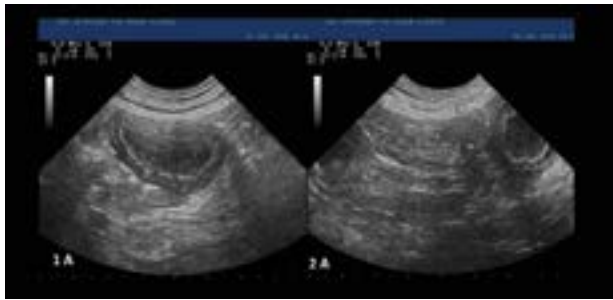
1A Ultrasonographic image of abdominal mass in Case 1, 1B: Ultrasonographic image of remnant right ovarian tissue in Case 1
